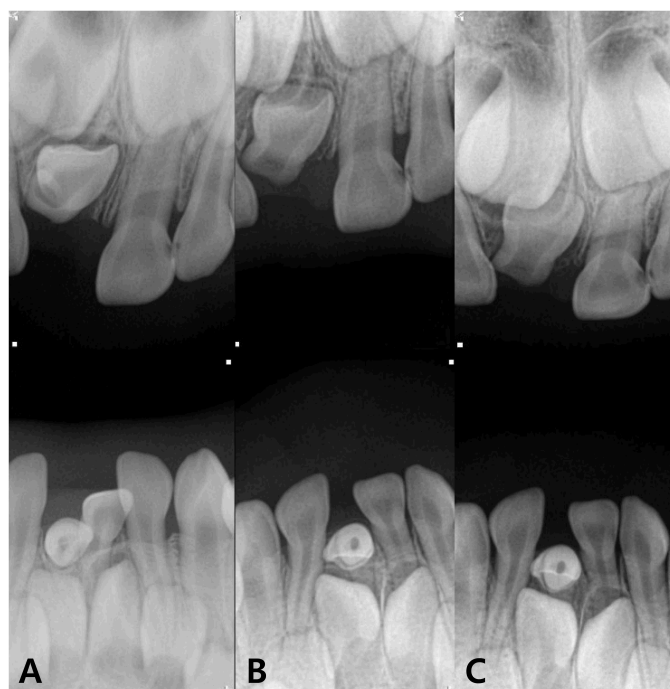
Periapical radiograph of the primary incisors. (A) Lingual eruption of tooth #71 (3Y 3M). (B) Tooth #71 spontaneously fully erupted (4Y 7M). (C) Movement of the successive permanent teeth #11 and #41 in the alveolar bone (5Y 1M).
